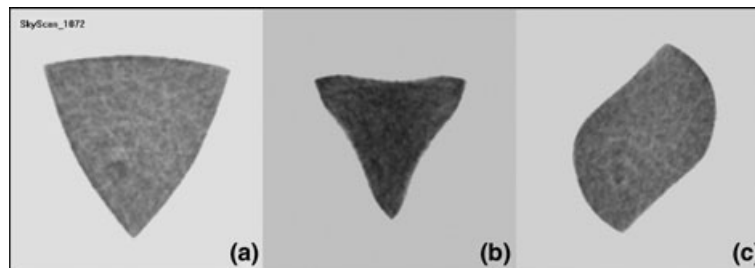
Cross-section obtained by means of μ CT scanning and reconstruction of a ProTaper F2 instrument showing the convex triangular design (a), of a ProTaper F3 instrument showing the modified triangular design with deeper flutes (b) and of a *Mtwo* size 25, 0.06 taper instrument showing the two blade cutting surfaces resulting in an 'Italic S' design (c).
